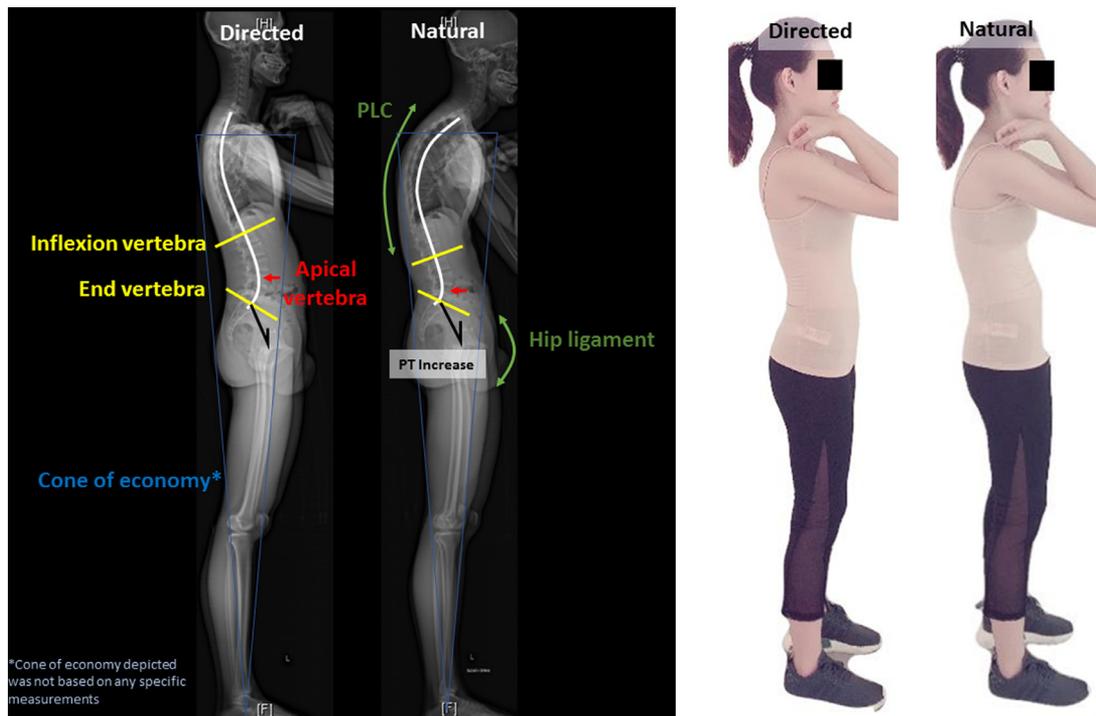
Radiographic and real-life representation of changes when transitioning from a directed to a natural/relaxed standing posture. PLC, posterior ligamentous complex.
